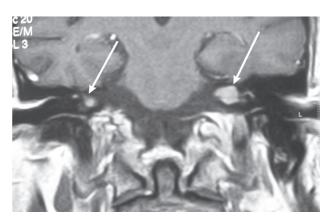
MRI showing lesions in internal acoustic meatuses bilaterally (arrows).
